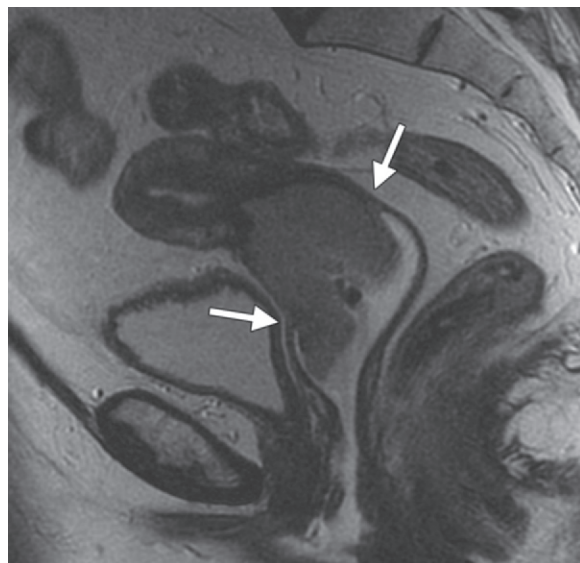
Use of endovaginal gel. Sagittal high-resolution T2-weighted FRFSE MR image shows a large mass replacing the anterior and posterior cervical lips and protruding into the upper one-third of the vagina. The high-signal-intensity endovaginal gel distends the vaginal fornices (arrows) and separates them from the intravaginal exophytic component of the tumor. The vaginal wall and forniceal insertions are separate from the tumor, and the normal low signal intensity of the muscular vaginal wall is preserved, excluding vaginal invasion.
